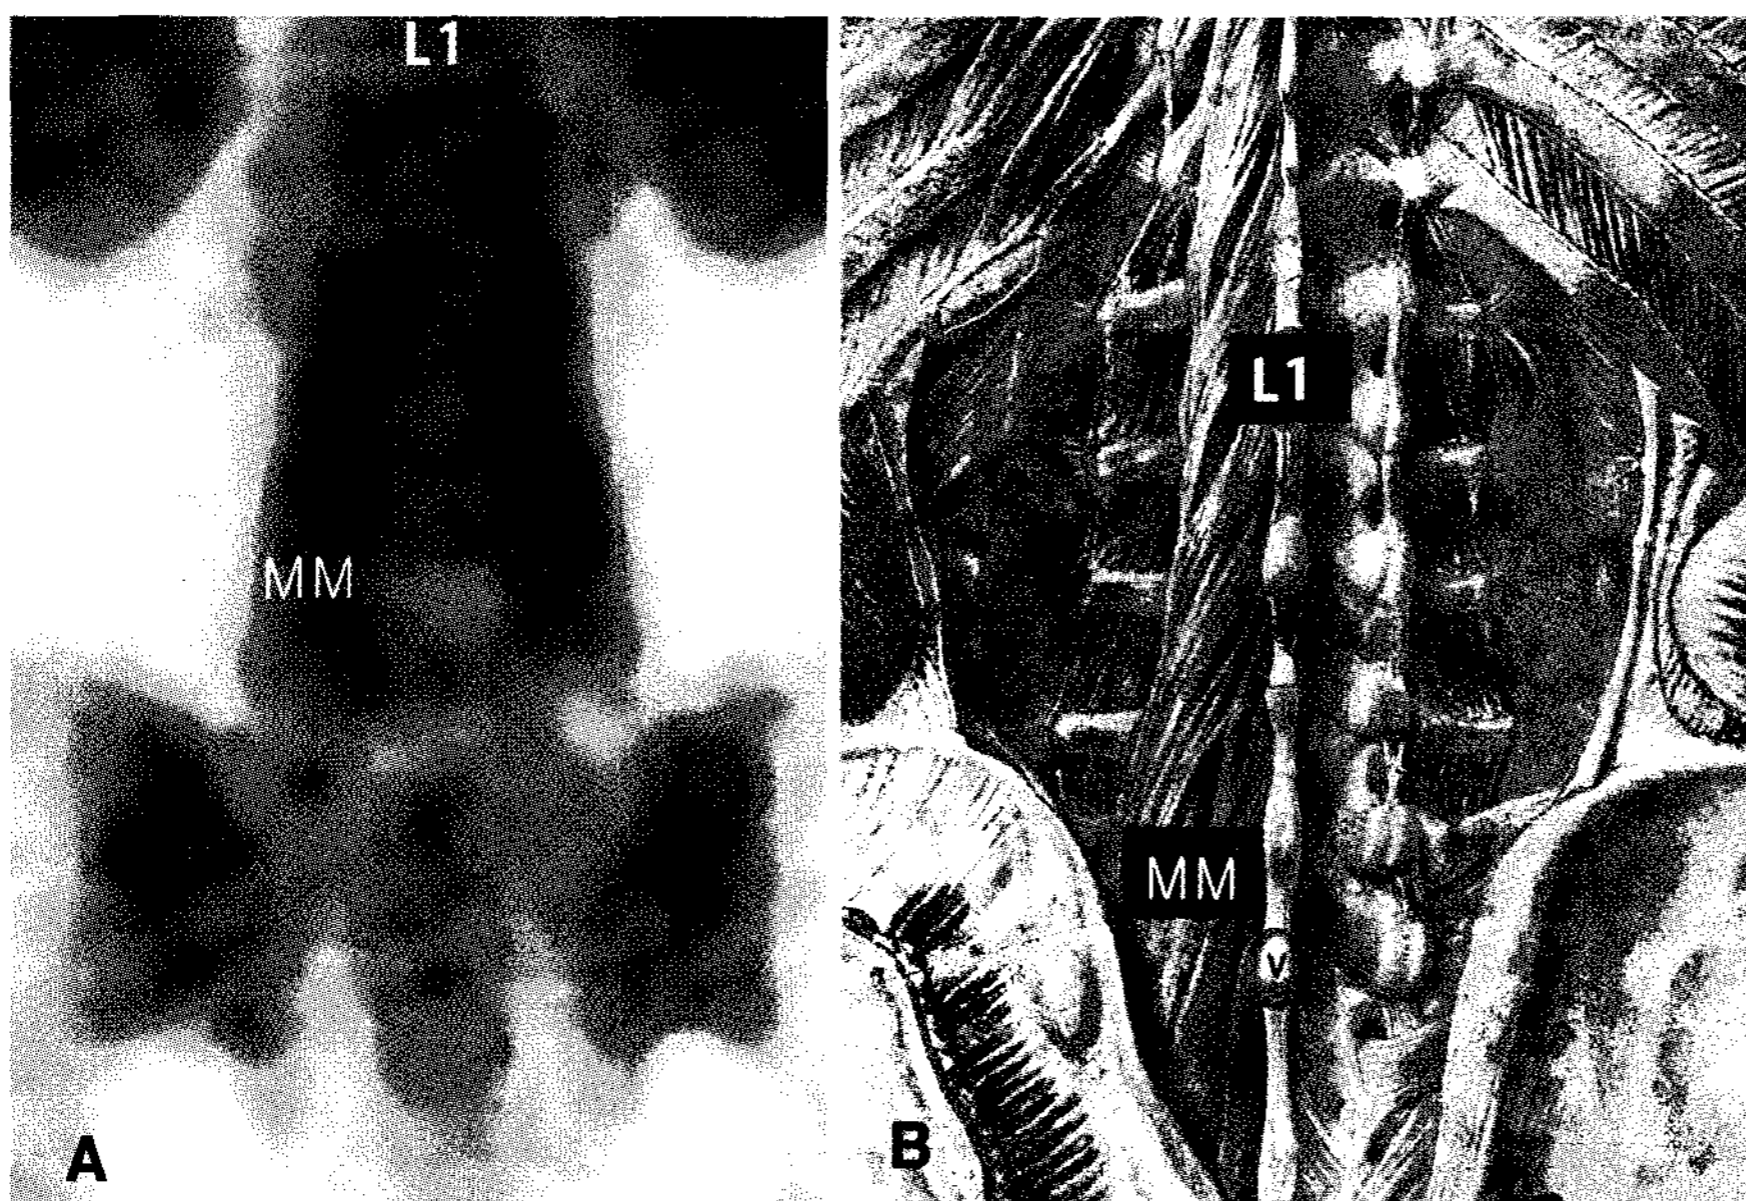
(A) Magnified scan identifies multifidus muscles (MM), L1 is 1st lumbar vertebra (B) Topograph. Adapted with permission from Sobotta: Atlas der Anatomie des Menschen. Elsevier GmbH, Urban & Fischer Verlag Munich. (CT/sma/March2008).
